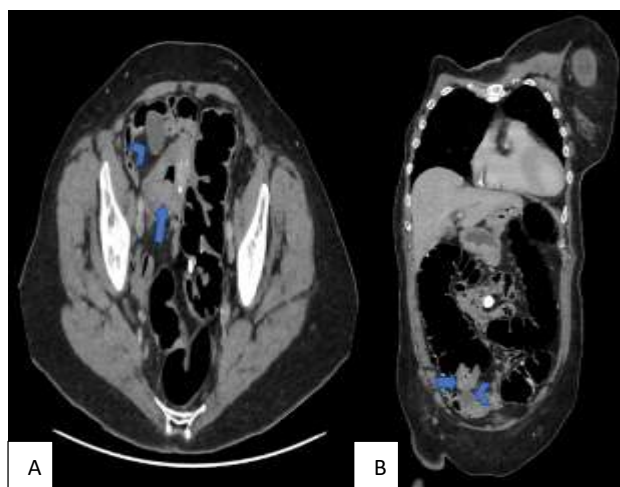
(A and B): Abdominal CT revealed a caecal tumour (arrow) and cystic mass in the appendix (arrowhead), indicating coexistence of GCA involving caecum and LAMN of appendix.
